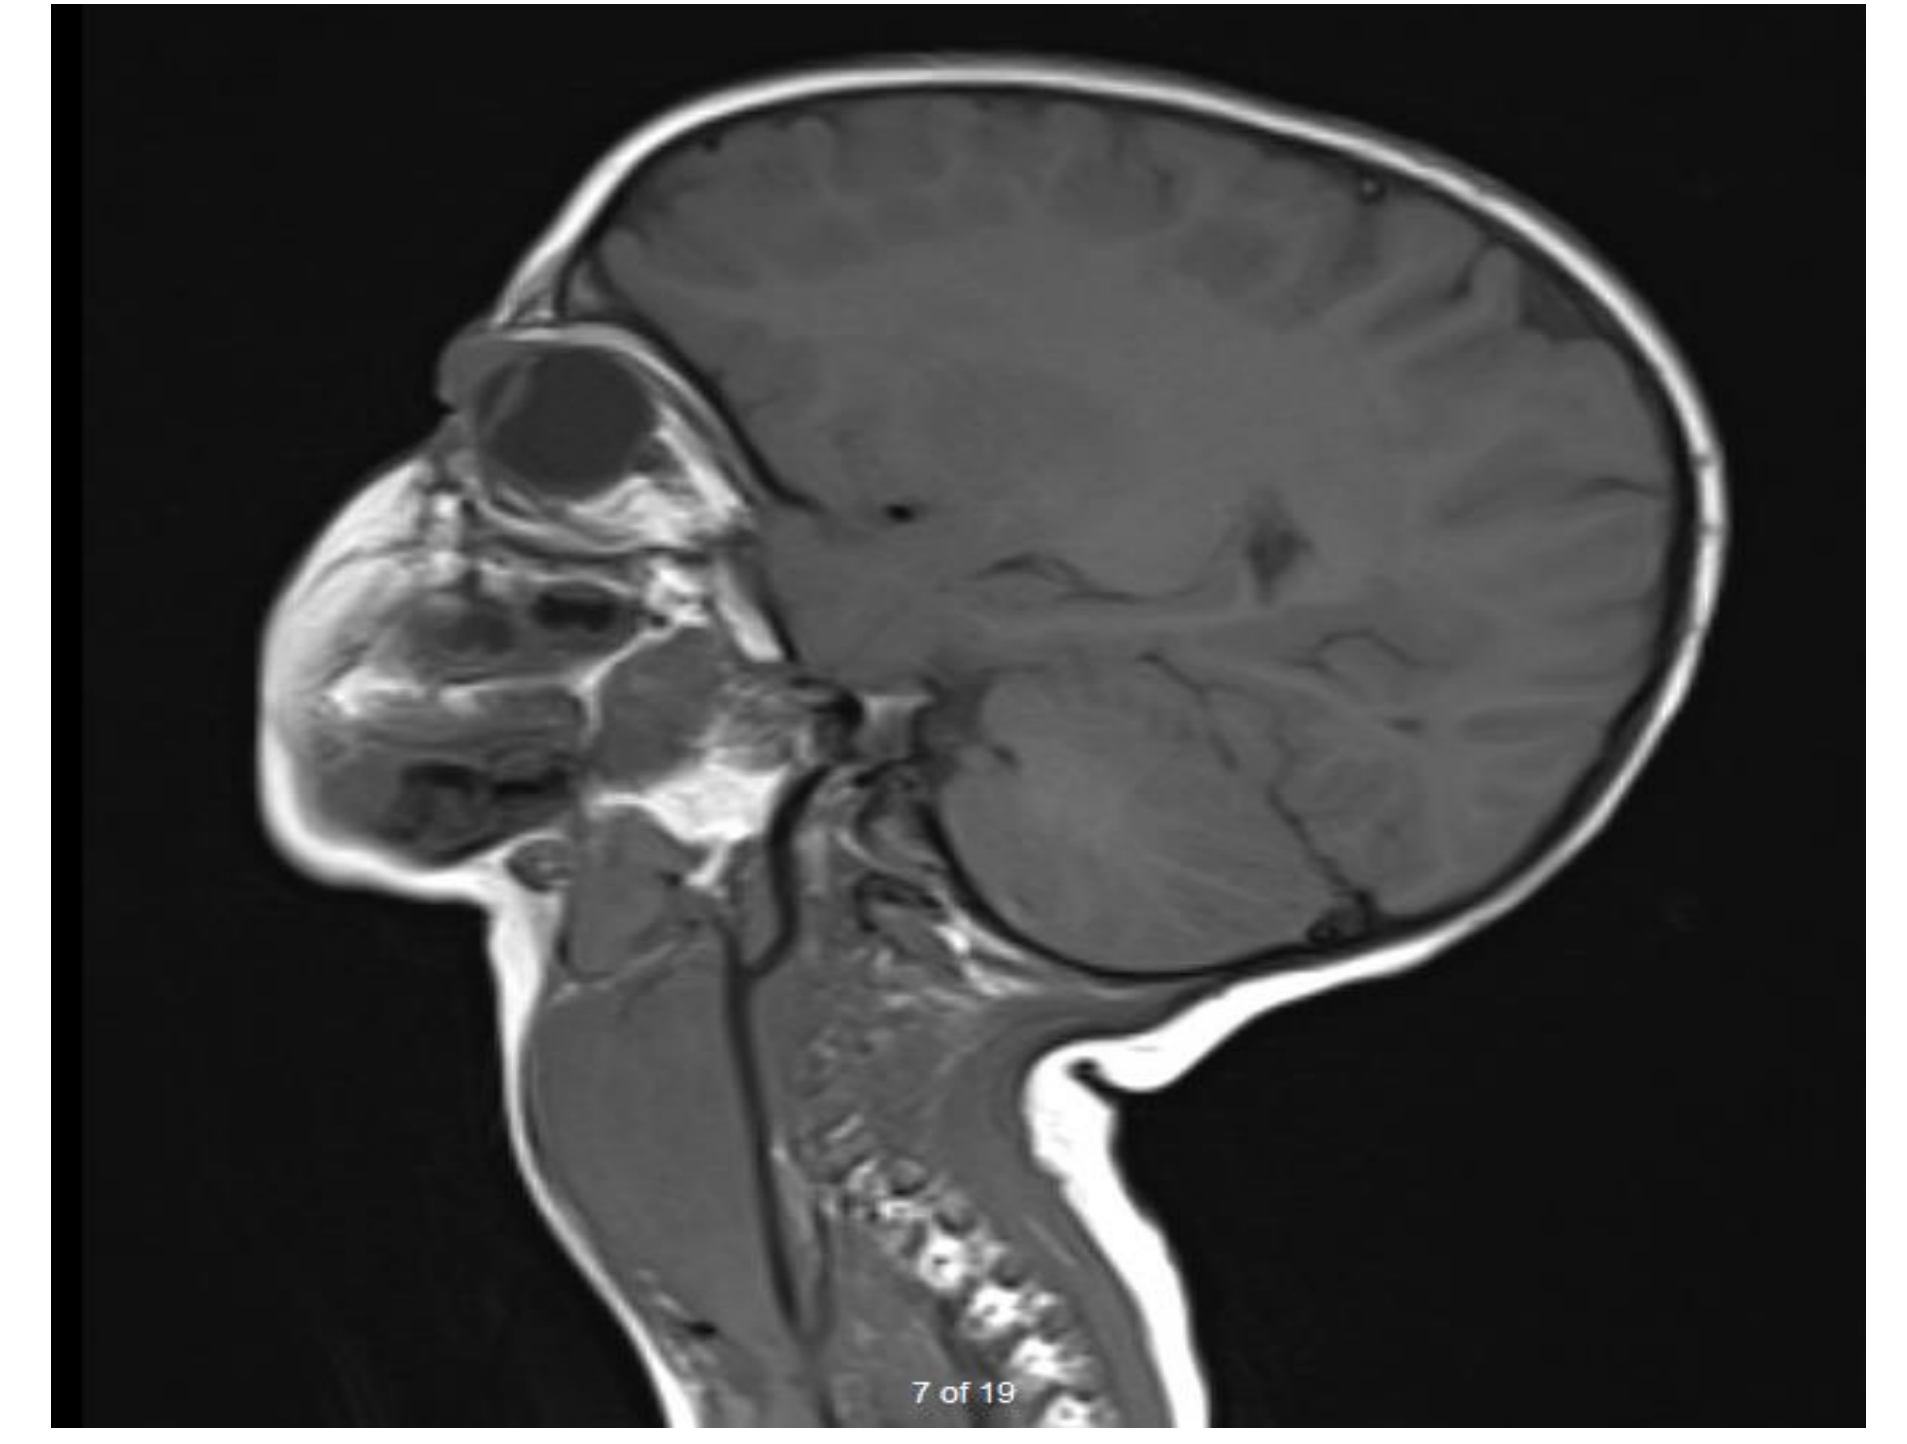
Sagittal MRI brain and neck demonstrating prominent neck mass
